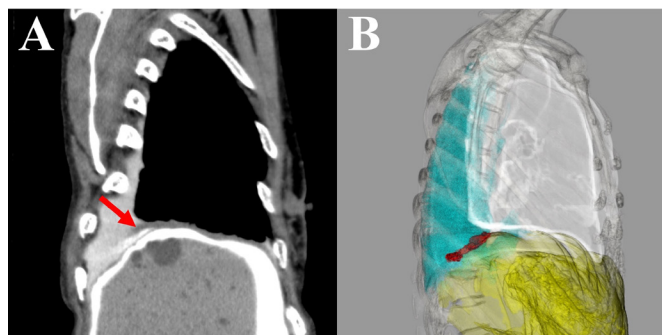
CT peritoneography. (A) Sagittal view showing a jet of contrast material (red arrow). (B) A three-dimensional reconstructed image showing the whole image with a jet of contrast material (red linear mass).
